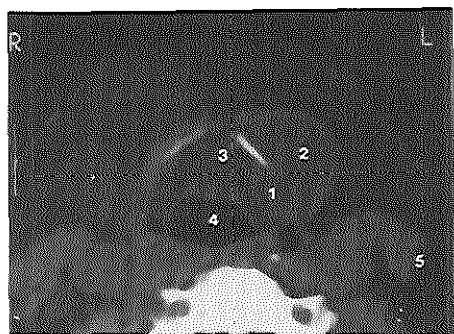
Transverse CT section at the level of the thyroid cartilage in the same patient.
